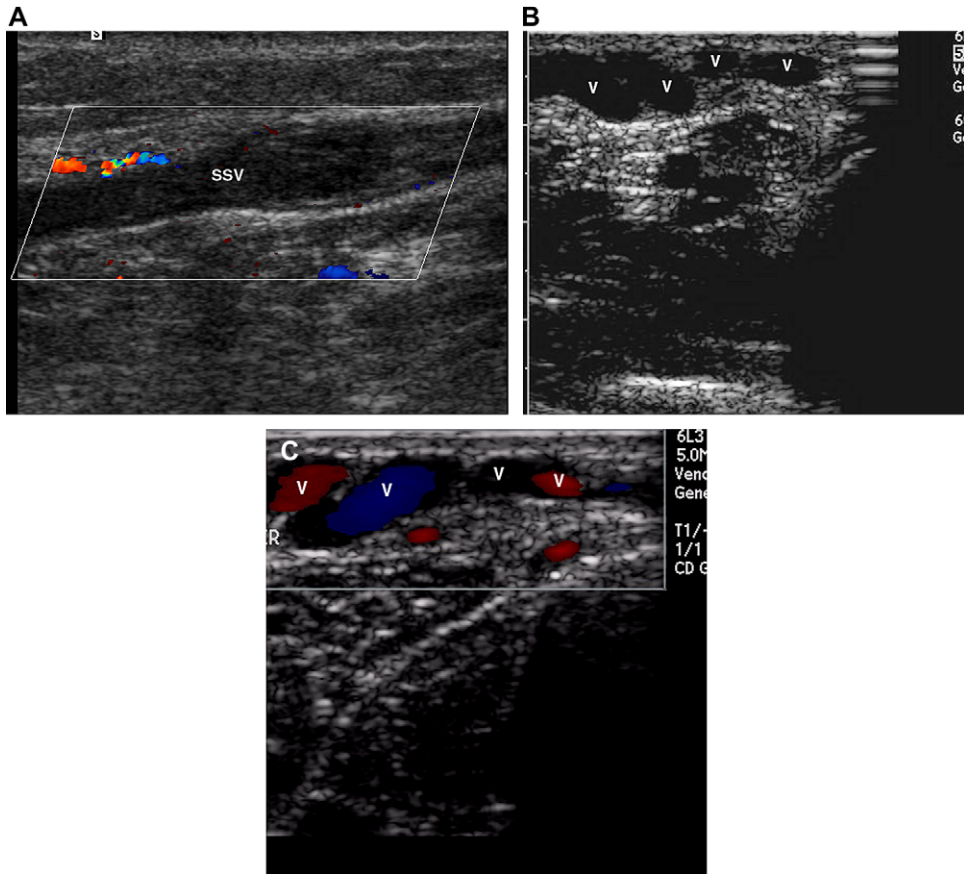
(A) Sagittal view of a thrombosed small saphenous vein (SSV) mistaken for popliteal vein thrombosis. Note the very superficial location of the small saphenous vein and absence of an accompany artery. (B) Grayscale image and (C) color Doppler US of superficial varicosities (V) causing pain and swelling, thus clinically mimicking DVT.
